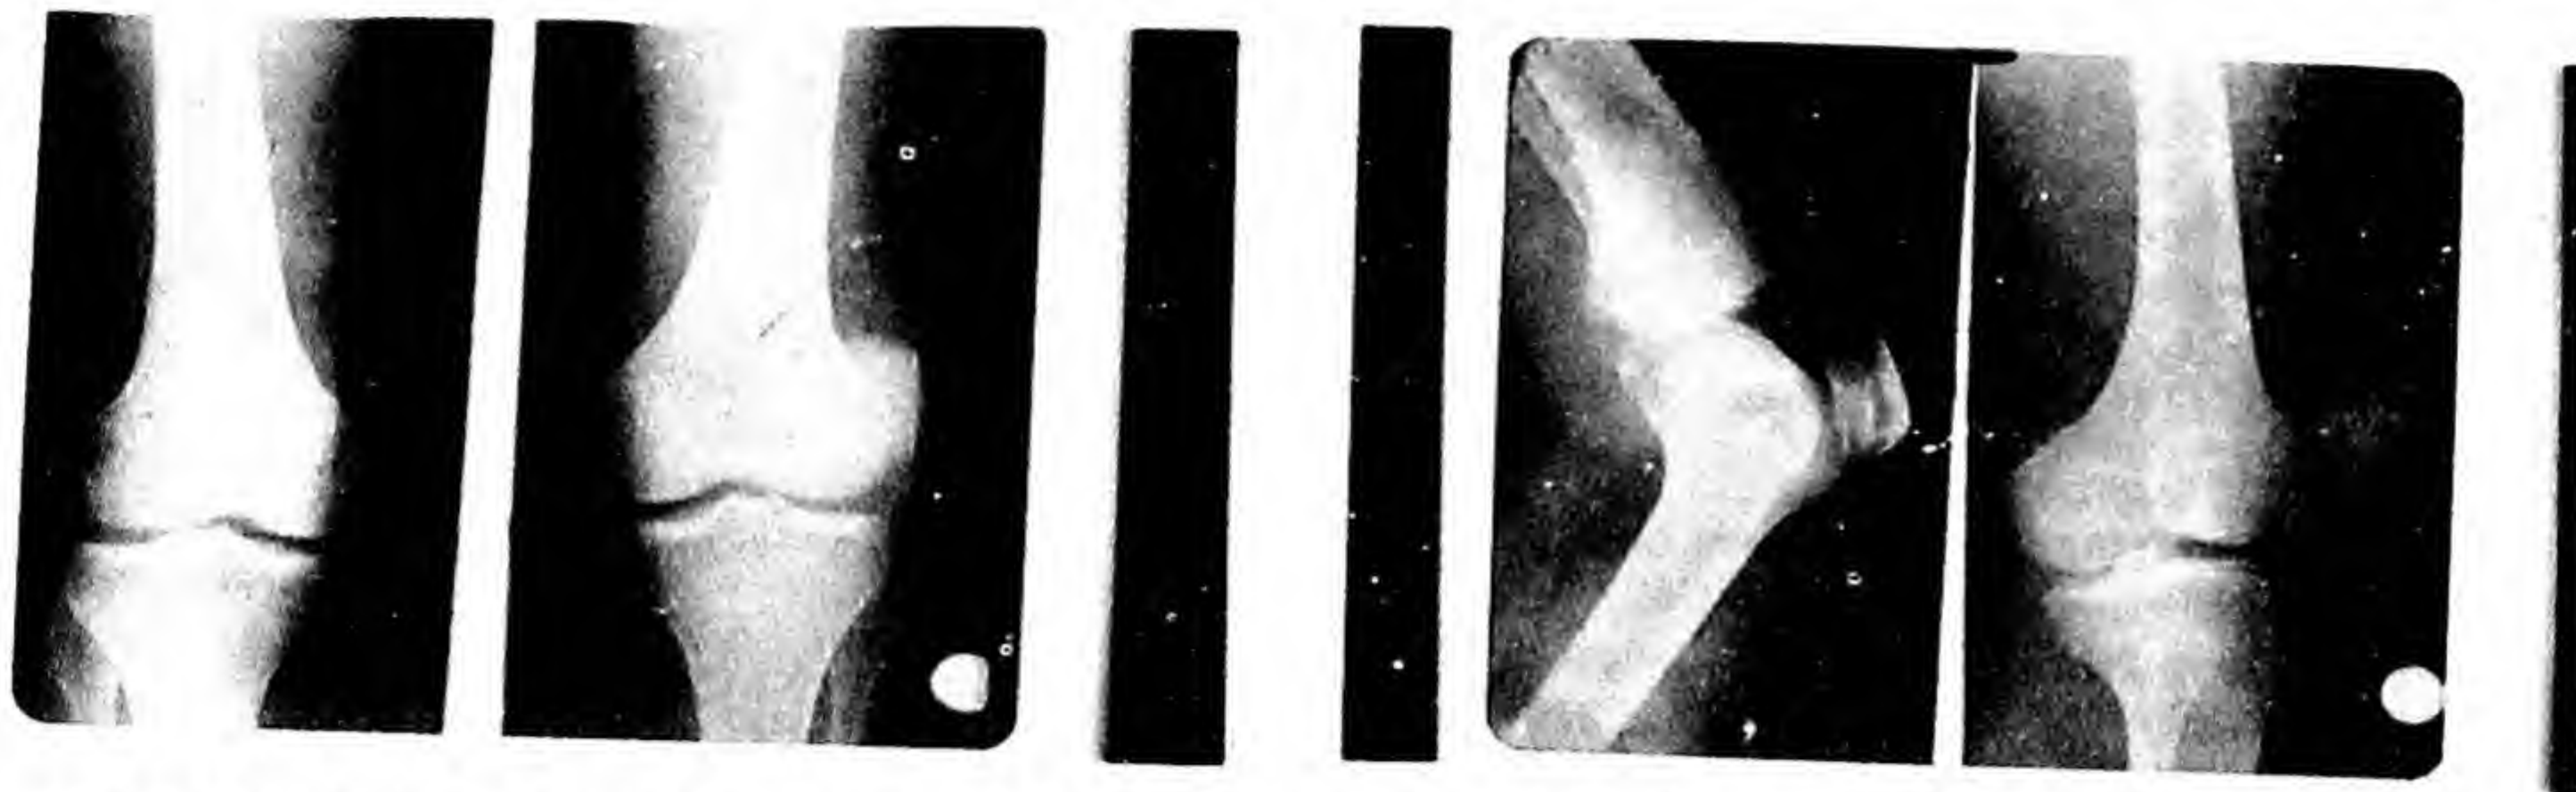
X-ray antero-posterior view of both knees showing vertical dislocation of patella on right side.
